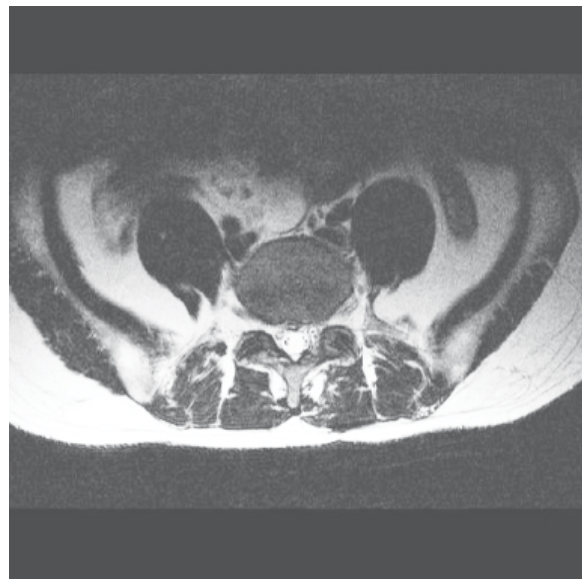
A magnetic resonance imaging (MRI) showed degenerative disc disease at L4/5 levels with posterior annular tear and focal central disc protrusion.
